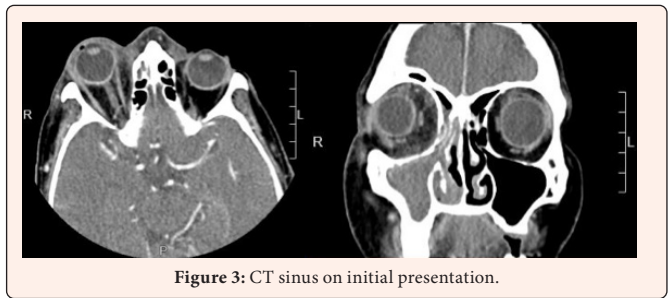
CT sinus on initial presentation.
